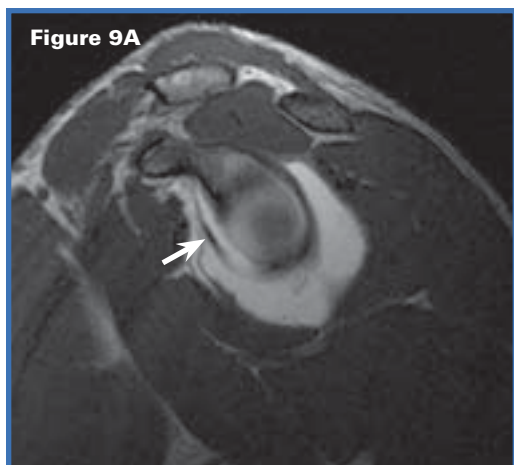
Spin-echo T1-weighted images in the axial plane (Figure 9A), oblique sagittal plane (Figure 9B), and abduction external rotation position after intra-articular administration of dilute gadolinium (Figure 9C) demonstrate an anterior labral periosteal sleeve avulsion injury (arrows).
